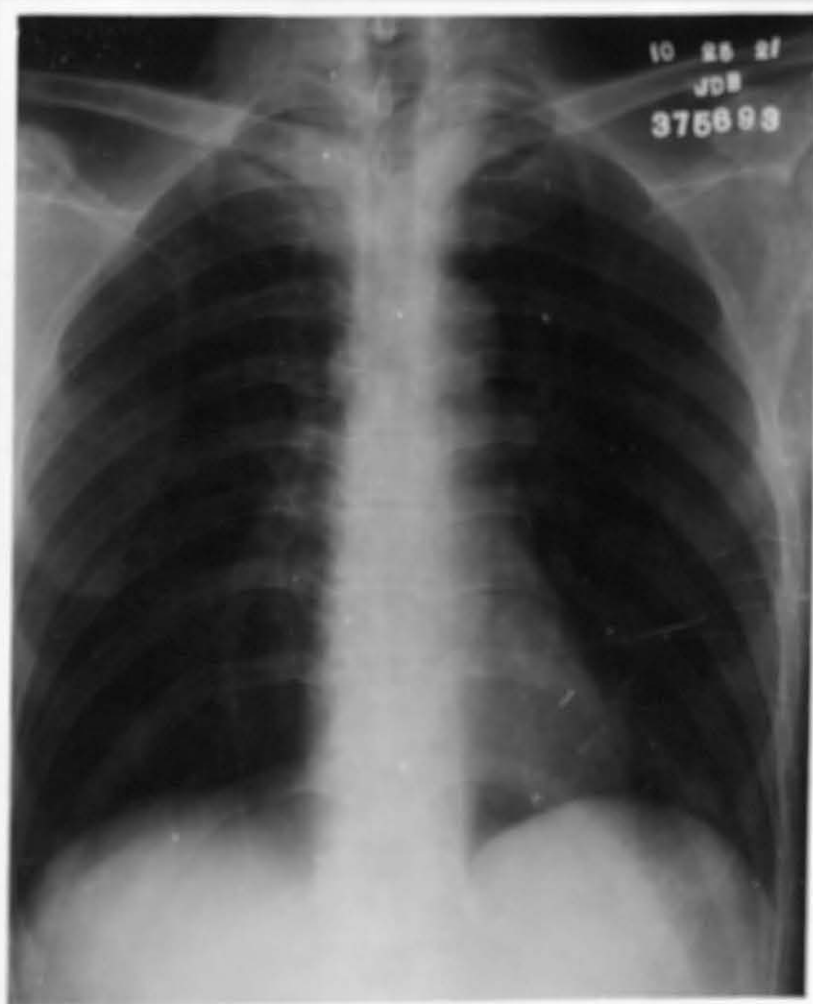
(Case 375693). Roentgenogram of spine of Spondylitis shown in Figure 26.
